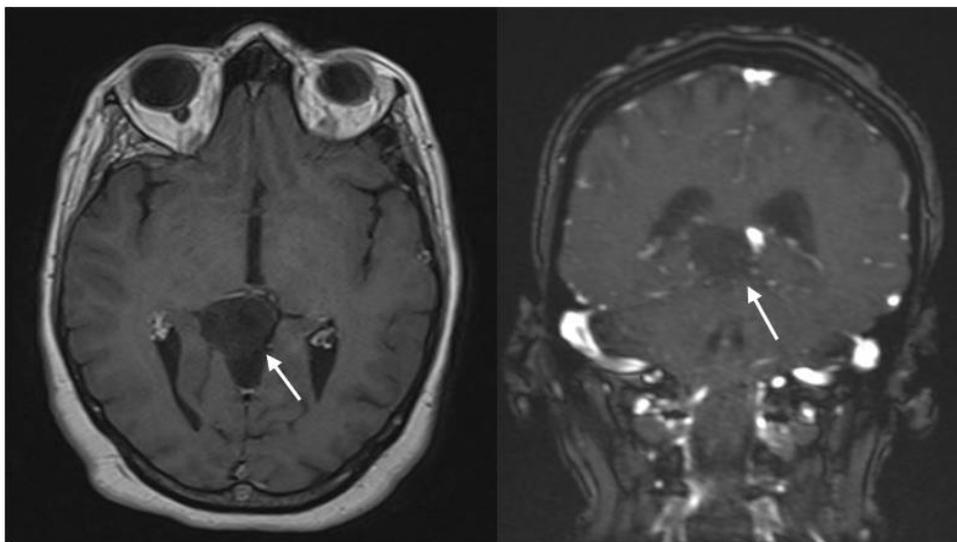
Axial postcontrast T1-weighted MR image showing the pineal cyst hypointense with no contrast enhancement
